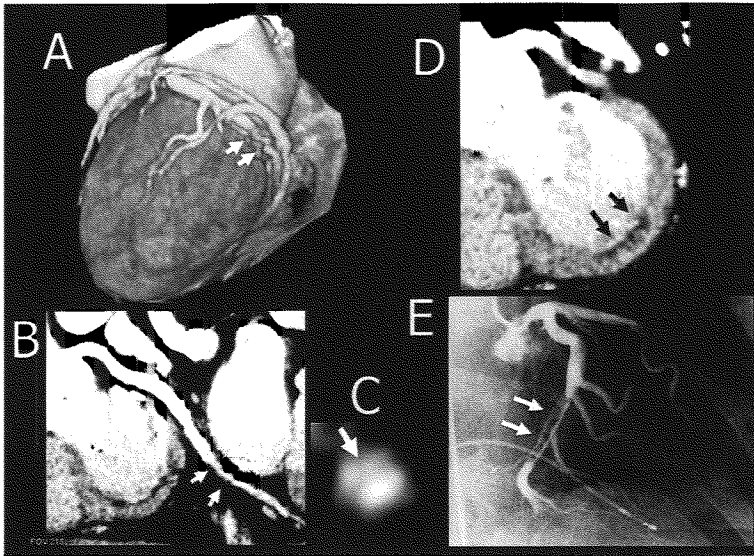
A 48-year-old man with non-ST-segment elevation myocardial infarction. Volume rendering (A) and curved multiplanar reformation (B) images show stenosis in the distal portion of the left circumflex artery (arrows). An axial image (C) shows stenosis with a CT-low-density plaque (42 HU, arrow). A short-axis image of the left ventricle (D) shows a thin-layered subendomyocardial contrast defect in the infero-lateral left ventricular wall (arrows). Coronary angiography (E) shows patent left circumflex artery but a large thrombus (arrows).
